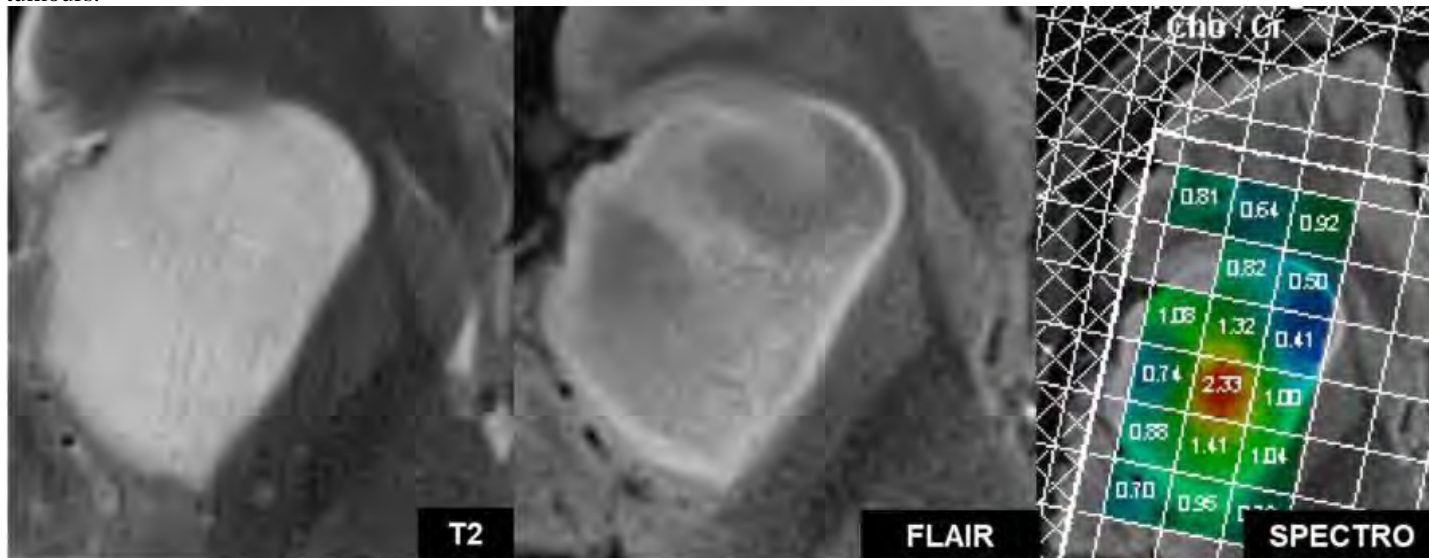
Panel showing classical T2-FLAIR mismatch tumour, confirmed IDH mutant 1p19q non codeleted ATRX mutant astrocytoma. Fairly homogeneous central T2 is shown with variable internal FLAIR suppression. Areas of greatest FLAIR suppression corresponded to lowest choline/creatine (Cho/Cr); areas of non FLAIR suppression corresponded to low ADC (not shown) and highest Cho/Cr, suggesting the greatest amount of cellularity/activity in certain areas of the core.
